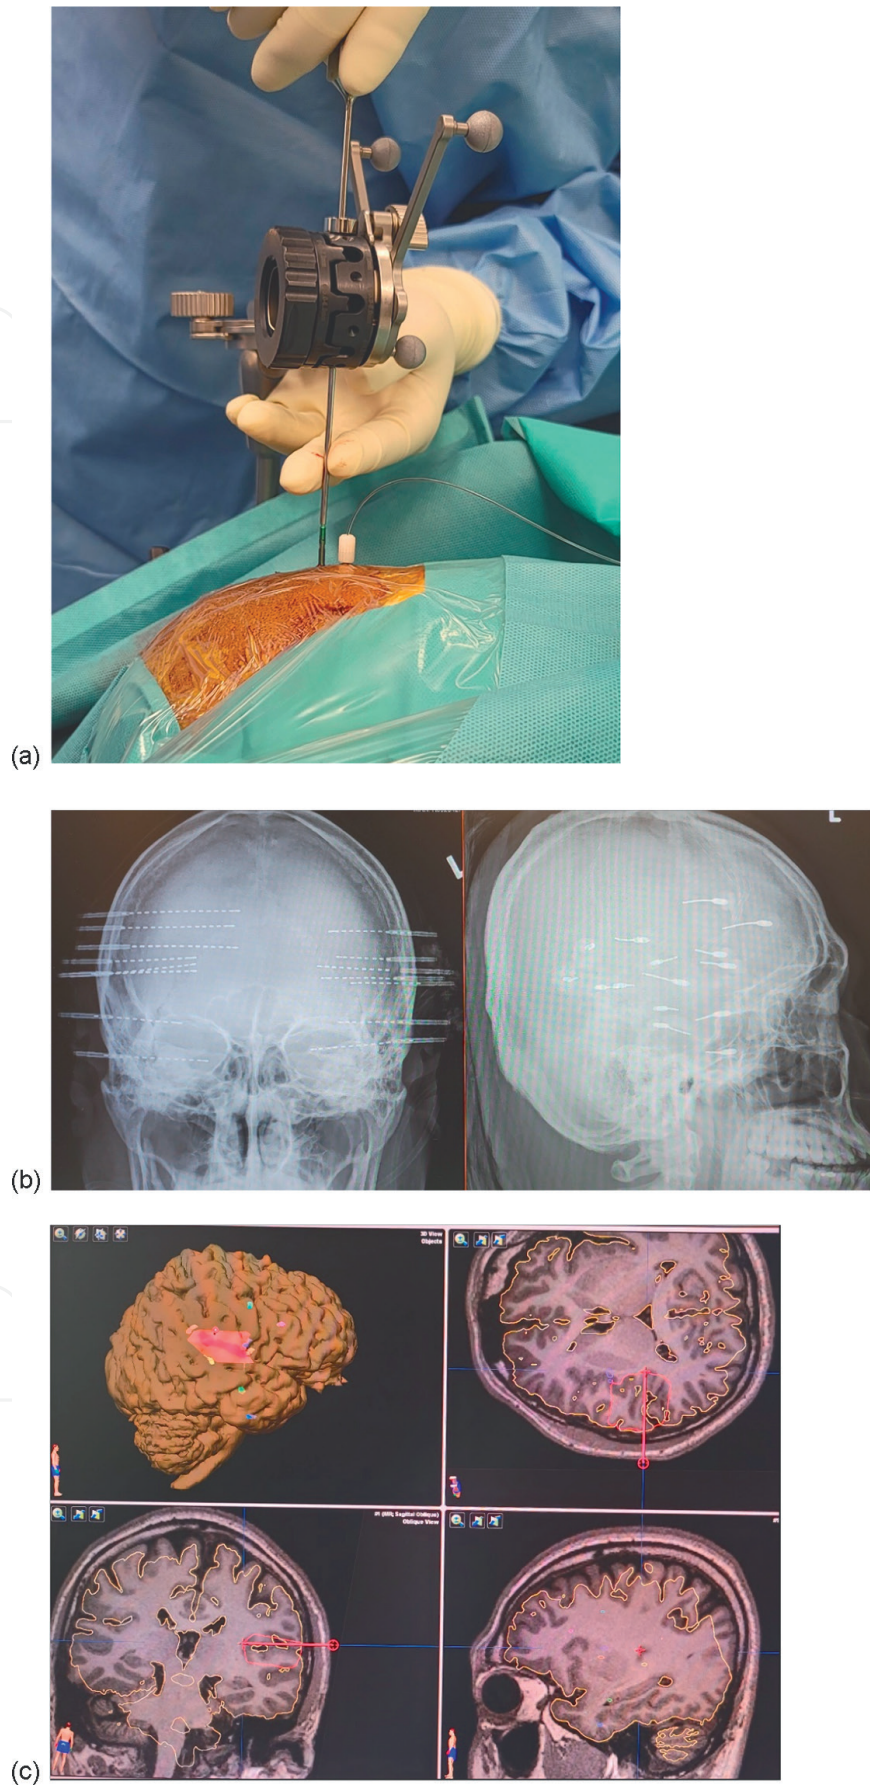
Stereo-electroencephalography (SEEG) implantation in a patient with suspected right posterior temporal cryptogenic epilepsy (SEEG implantation) (a); post-implantation skull X-ray (b); and SEEG position coregistration with postulated epileptogenic zone in the neuro-navigation system (c).
